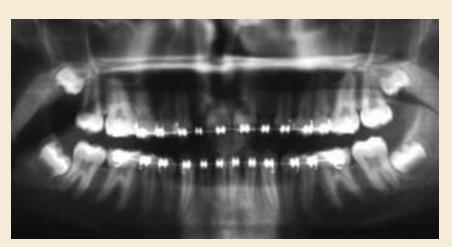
Preoperative, postorthodontic panoramic radiograph.
